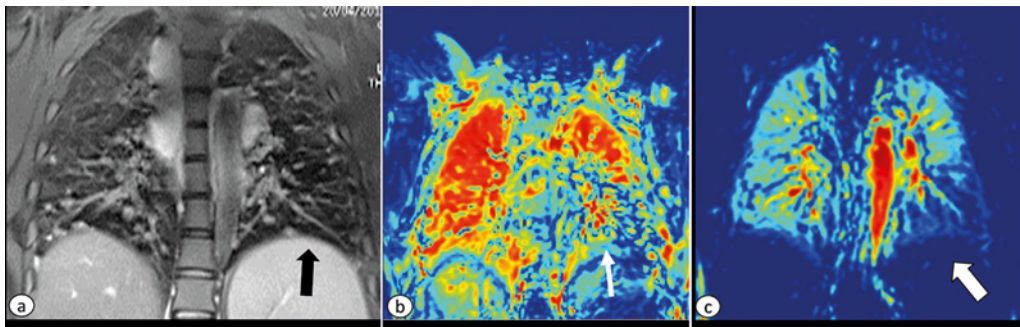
Fourier Decomposition. PROPELLER/ BLADE MRI (a) and FOURIER DECOMPOSITION MRI ventilation (b) and perfusion (c) maps, in patient with common variable immunodeficiency (CVID). Note in the morphological image darker area in the left lower lobe (black arrow), which consists of area of trapped air. In the correspondent ventilation map that area appears not ventilated (white thin arrow). The same area in the perfusion map shows reduced perfusion (thick white arrow), according the physiologic reflex of hypoxic vasoconstriction. Courtesy of Giovanni Morana, Ca' Foncello Treviso Hospital.
